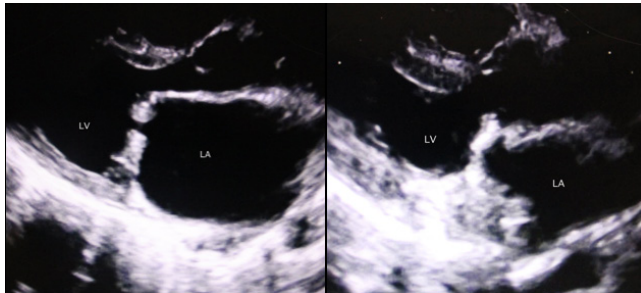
The transthoracic echocardiogram images. The image on the left was taken pre-operatively showing a dilated left atrium (LA). The image on the right showed a decrease in the LA size after surgery.
